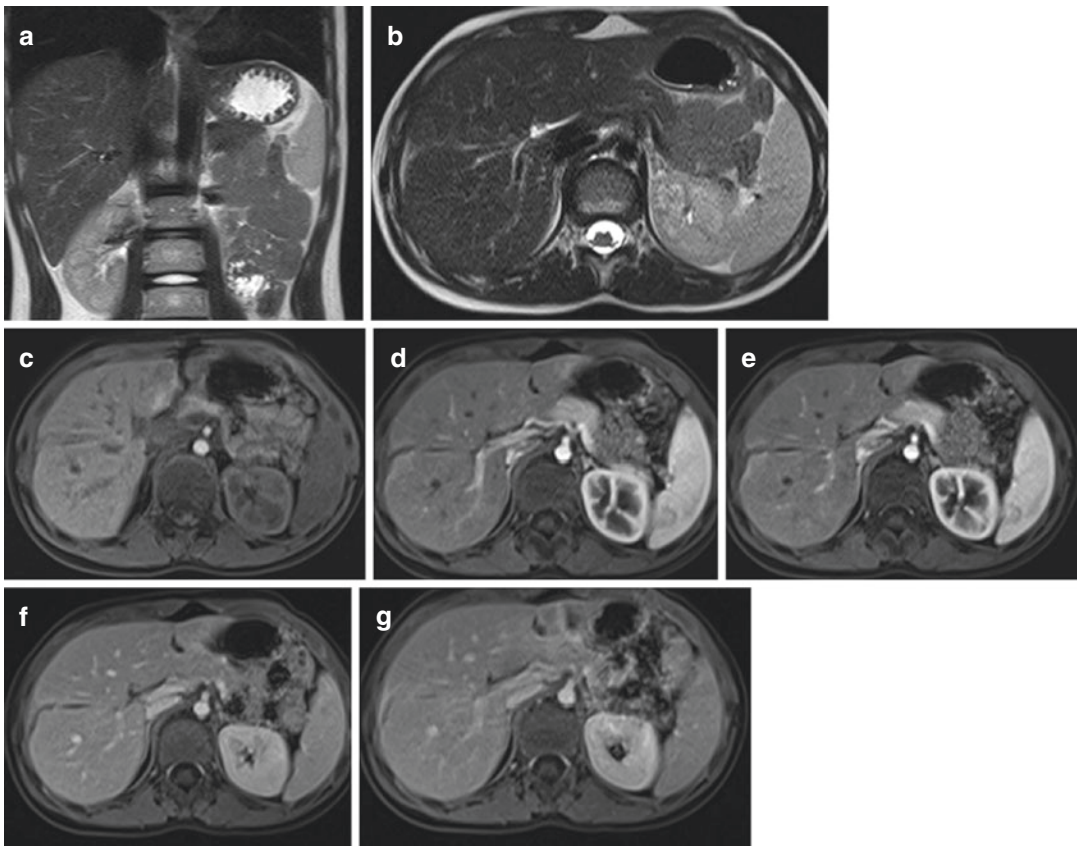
Follow-up with MRI after 1 month. In HASTE T₂-weighted images (a, b) and VIBE T₁-weighted images (c–g) after contrast media administration, the results of the right lobe laceration are still apparent, with persistent linear parenchymal hypointensity, reaching the capsule, that appears thickened. There is still a thin, perihepatic fluid collection, best seen in T₂ images
